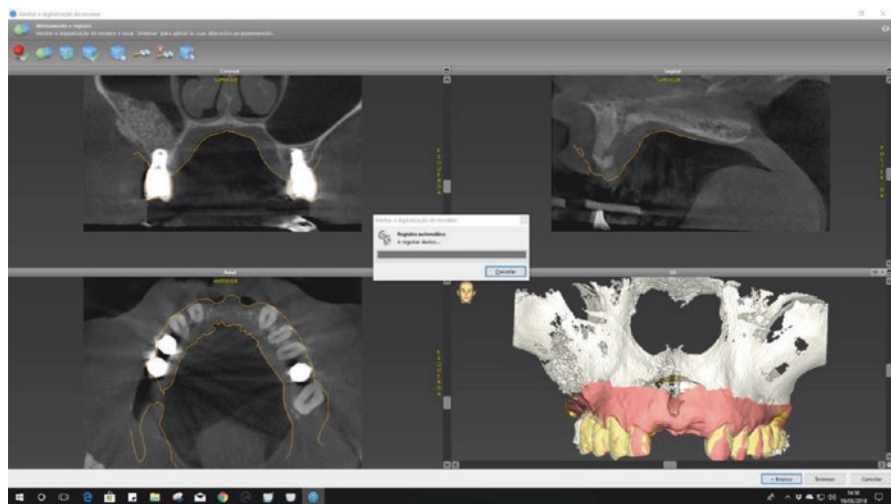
Combination of STL (from intraoral scanning procedures) and DICOM files (from CBCT), viewed in the Dental Wings coDiagnostiX® software. The yellow lines overlapping DICOM images depict soft tissue information taken from STL files (Courtesy by *Doc Digital* radiologic center)
